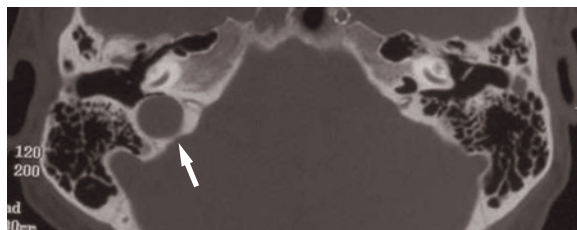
Axial CT scan. Large jugular bulb (arrow) on the right side (reproduced from Calzolari F., 2006,⁶ with permission of Omega Edizioni).
